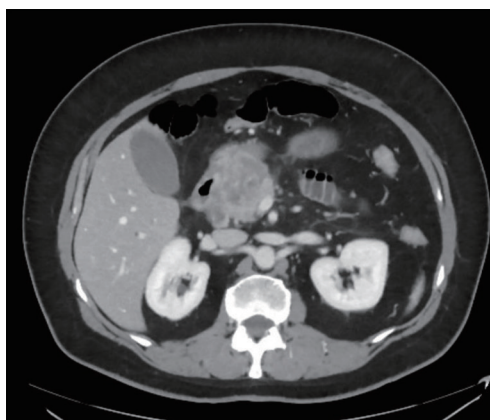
Patient's initial diagnostic CT scan on November 19, 2019 demonstrating his primary pancreas head lesion.
